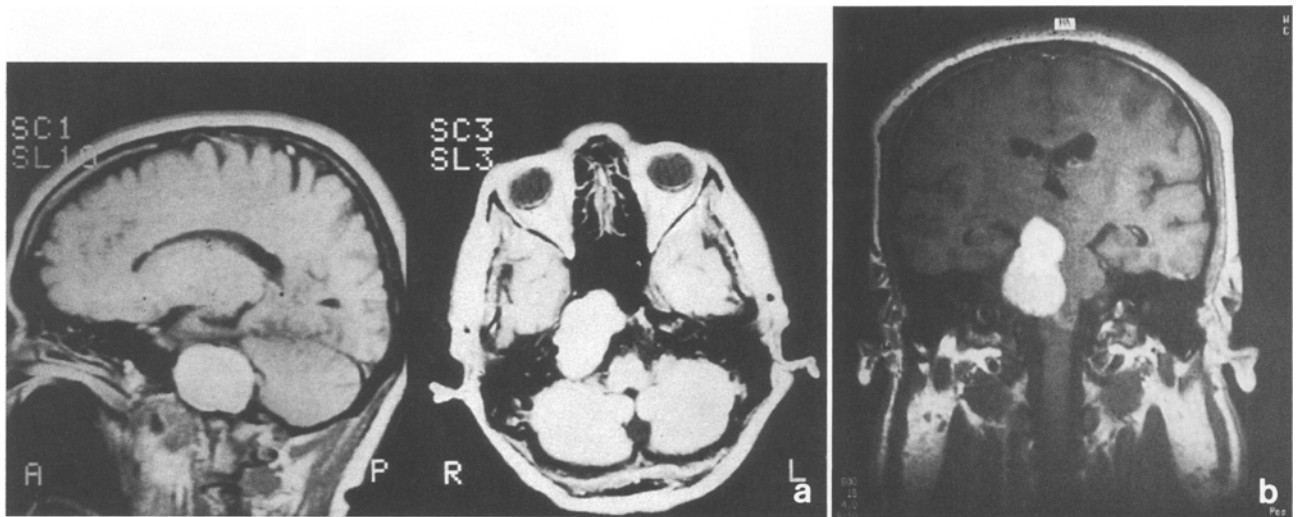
MRI with Gadolinium, T1 phase. (a) Sagittal and axial scans and (b) coronal scan, give evidence of this huge dumb-bell trigeminal neurinoma arising from Meckel's cave on the right side
